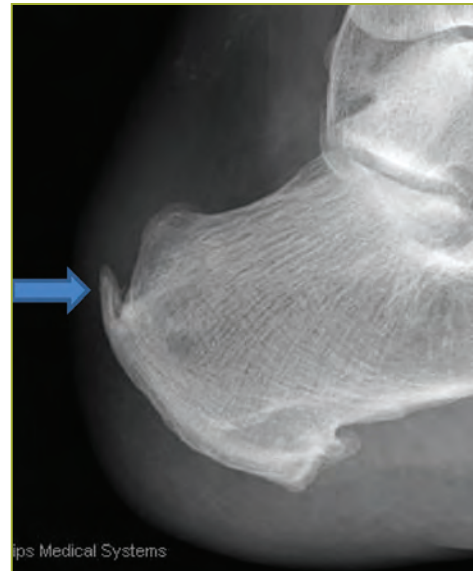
Radiograph showing posterior calcaneal osteophyte (arrow), seen in seven of the eight patients with sleeve avulsion injuries.
